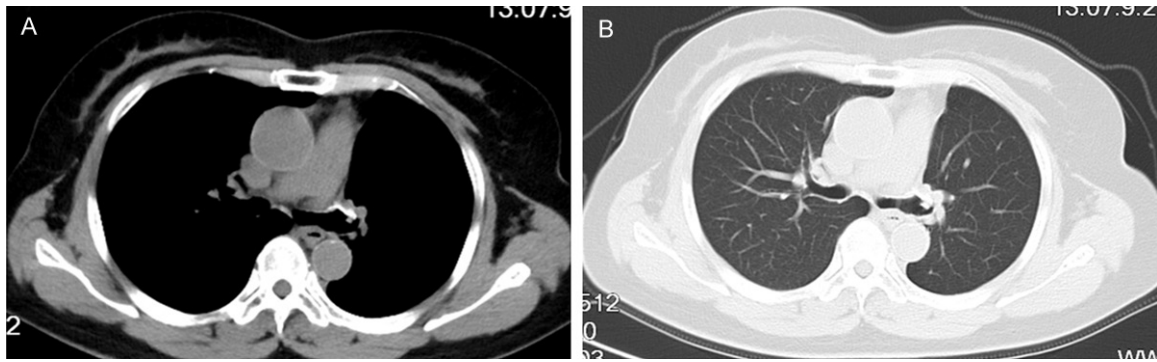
Chest computed tomography (CT) of the patient after she had been followed of 37 months. A. (mediastinal window) and B. (pulmonary window), without recurrence.
